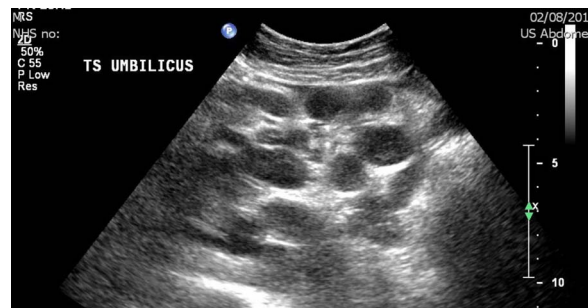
Multiple hypoechoic lesions on ultrasound scan representing large-volume para-aortic lymphadenopathy.
